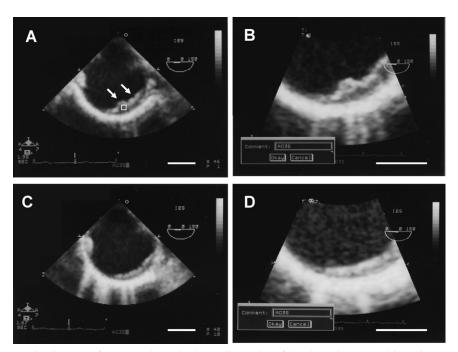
Representative images of transesophageal echocardiography of the thoracic aorta. This patient started warfarin 3 y before enrollment in the present study and continued warfarin during the study. (A) Plaque in the thoracic aorta at baseline. Arrow indicates the plaque. Square indicates region-of-interest. (B) An enlarged image of the plaque site in A. (C) The same plaque as in A after pitavastatin therapy. (D) An enlarged image of the plaque site in C. Bar = 1cm.
